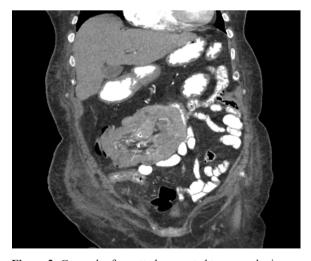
Coronal reformatted computed tomography image demonstrating the colo-colic intussusception (white arrow).
